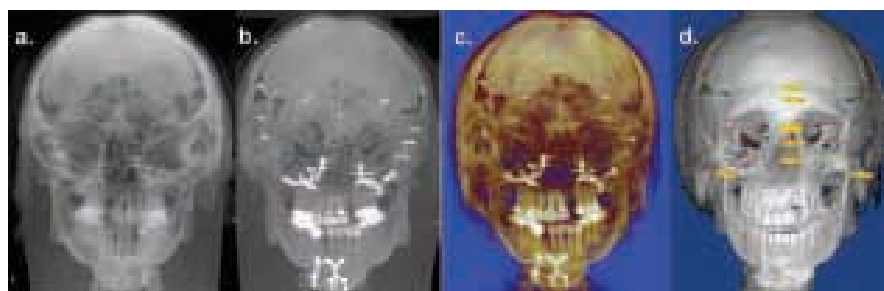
Comparison of 3D visualization techniques applied to CBCT dataset of a patient with a craniofacial deformity: Ray sum (a); maximum intensity projection (b); and 3D computer generated modeling including volumetric transparent and shaded surface display (c). 3D cephalometric measurements can be performed interactively on the volumetric representations (d) (Volumetric data set acquired with extended field of view i-CAT and all reconstructions generated using Dolphin 3D).
